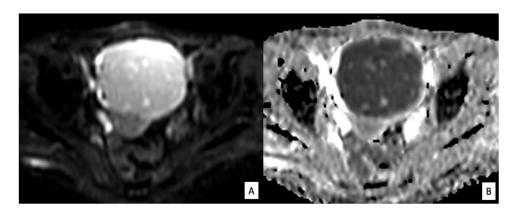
Axial DWI image (A) and ADC mapping (B) showing diffusion restriction of the mass with a low ADC value of 0.7×10^{-3} /mm².
